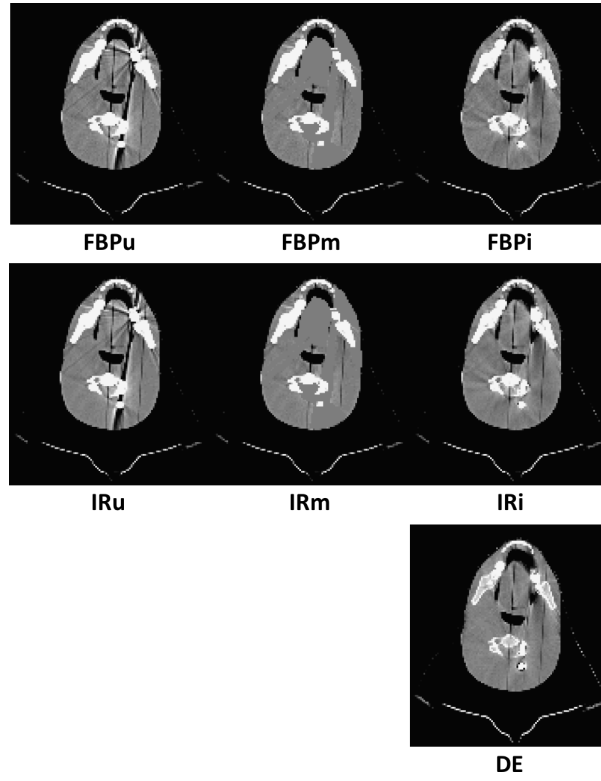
Effect of the seven approaches for dealing with metal artifacts investigated in this study on the same slice of Charlie's CT.
